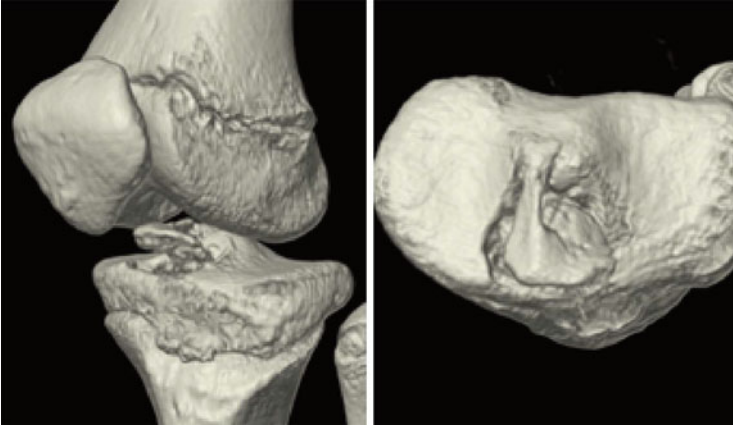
Computed tomography. Three-dimensional computed tomography image shows the displaced fragment and fracture site
